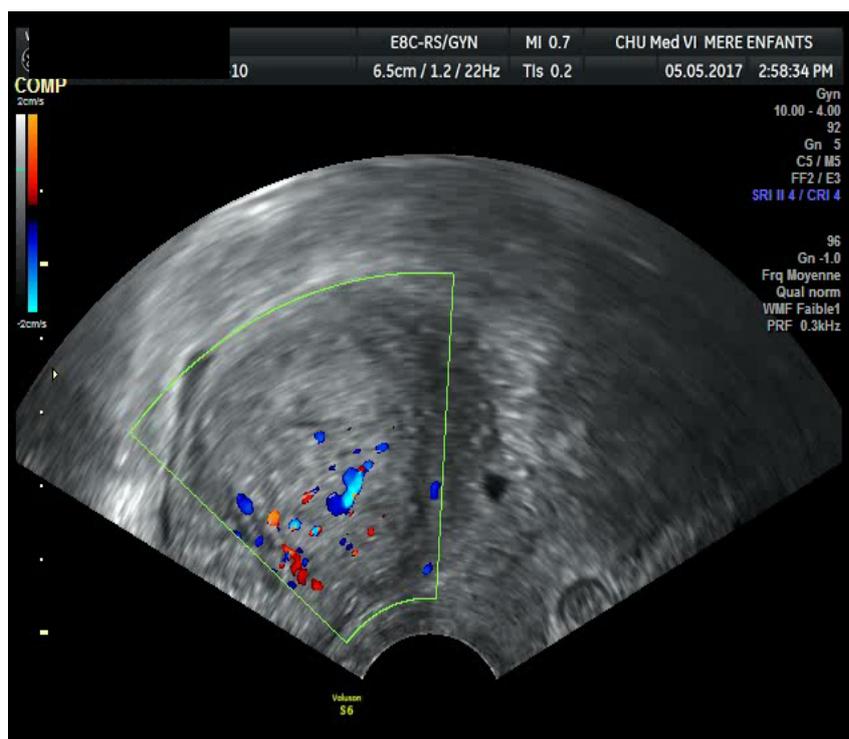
Image showing a heterogeneous suspicious image with central vascularization in the endometrium in color and power doppler ultrasonography. Obstetrics and gynecology department of Mohammed the sixth University Hospital of Marrakech.
